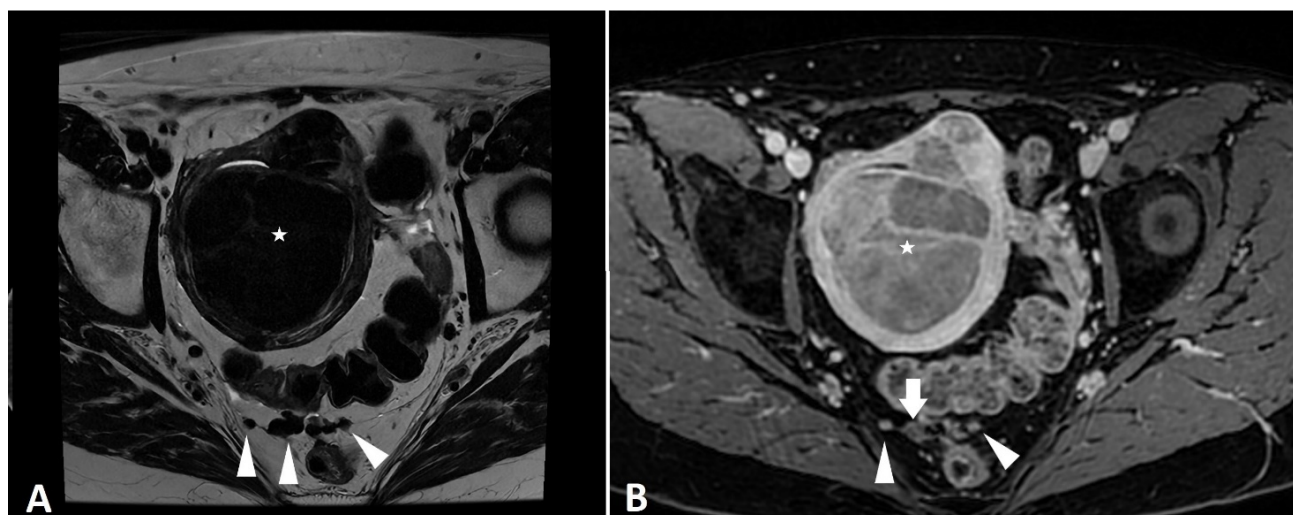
Another case of disseminated peritoneal leiomyomatosis. (A) Pelvis magnetic resonance imaging scan on axial plane (T2-weighted sequence) showing multiple small disseminated peritoneal leiomyomatosis (DPL) nodules partially confluent with each other and adherent to the peritoneum (arrowheads) in a patient with greatly enlarged uterus due to multiple large leiomyomas (star). (B) After intravenous administration of contrast medium the aforementioned DPL nodules either show homogeneous enhancement (arrowheads) or bland mainly peripheral enhancement (arrow), with a pattern not dissimilar to the larger uterine leiomyomas in the same section (star).
